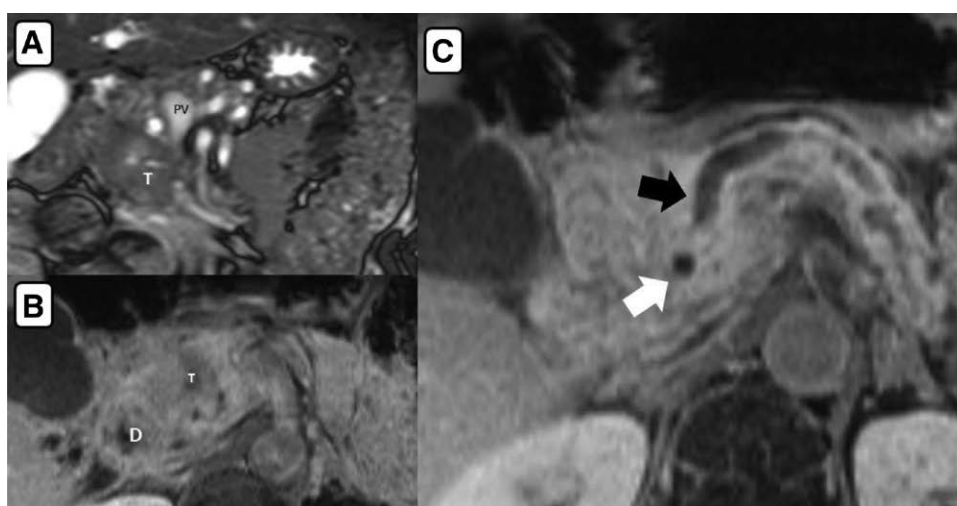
Magnetic resonance imaging (MRI) of a 61-yr-old male patient. (A) A 4 cm tumor (T) located in the head of the pancreas without evidence of vascular invasion. (B) Adjacent tissues surrounding the tumor (T); D: duodenum. (C) black arrow: dilated pancreatic duct; white arrow: CBD (Siemens Magnetom Avanto 1.5T MRI scanner, 1.5 Tesla field strength).
